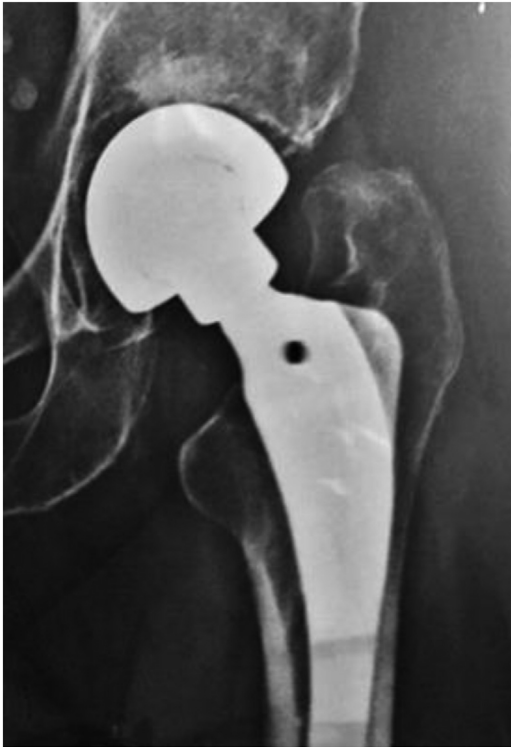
Patient's initial postoperative anteroposterior radiograph of a left hip bipolar hemiarthroplasty.
